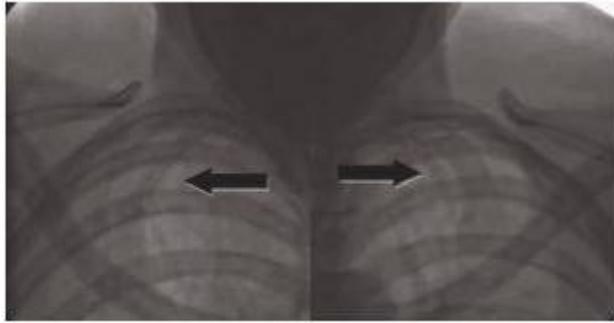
Apical lordotic chest x-ray (arrows indicate bilateral complete cervical rib)
